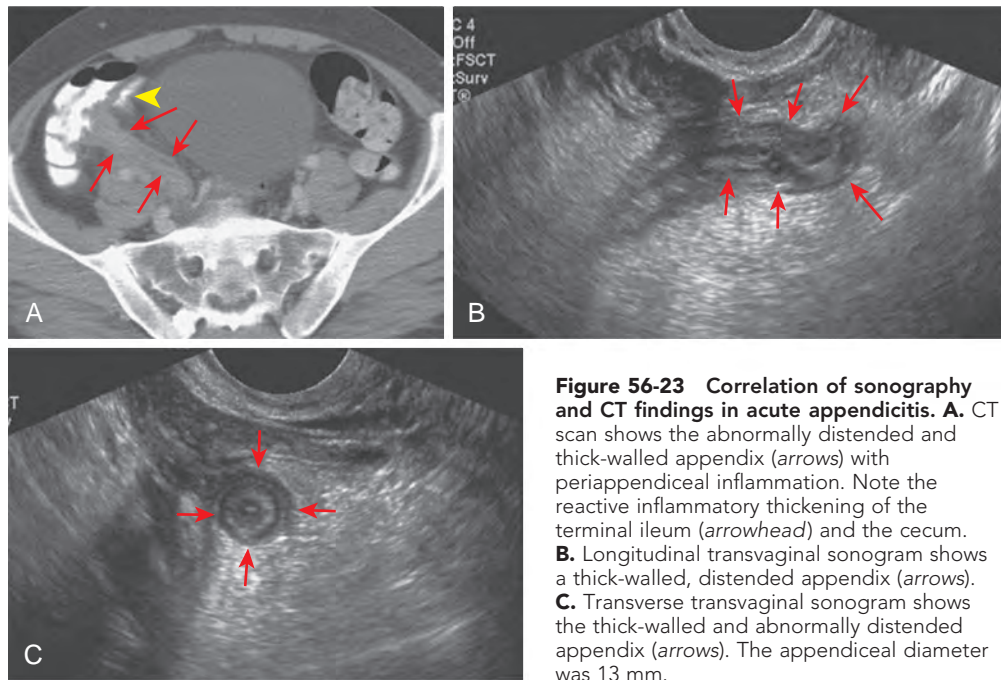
Correlation of sonography and CT findings in acute appendicitis. A. CT scan shows the abnormally distended and thick-walled appendix (arrows) with periappendiceal inflammation. Note the reactive inflammatory thickening of the terminal ileum (arrowhead) and the cecum. B. Longitudinal transvaginal sonogram shows a thick-walled, distended appendix (arrows). C. Transverse transvaginal sonogram shows the thick-walled and abnormally distended appendix (arrows). The appendiceal diameter was 13 mm.
